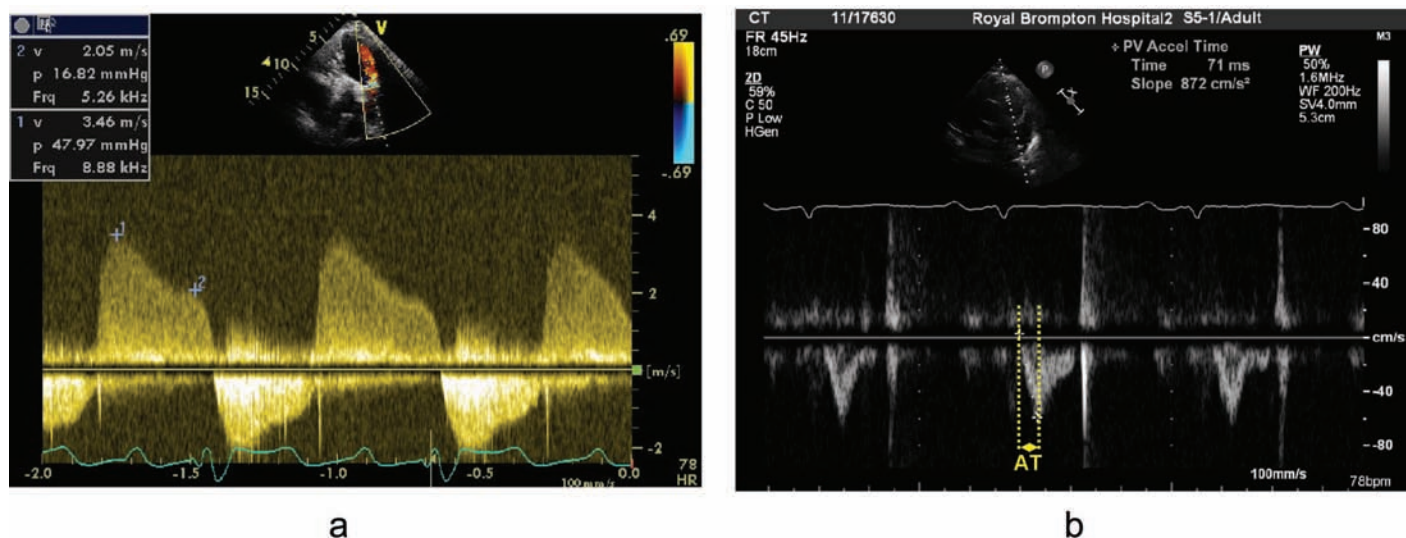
(a) Estimation of mean and diastolic pulmonary artery pressure by continuous-wave Doppler signal of pulmonary regurgitation (PR). Point 1 indicates maximal early diastolic PR velocity, which can be used to calculate MPAP. Point 2 marks end-diastole PR velocity used to calculate end-diastolic pulmonary artery pressure. (b) Measurement of pulmonary AT from the pulsed-wave Doppler signal of pulmonary arterial flow.
